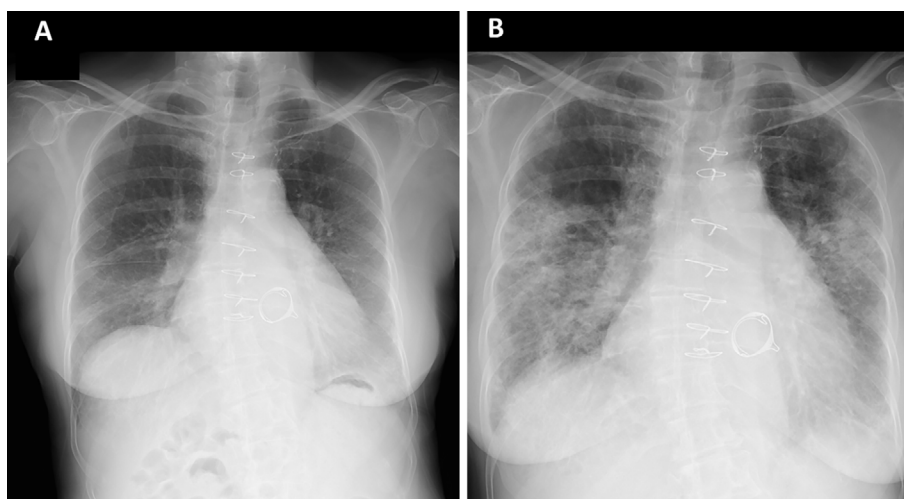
A chest radiograph taken before the start of bucillamine at the first visit to the local physician showing reticular shadows in the bilateral lower lung fields (A). A chest radiograph taken at initial presentation showing infiltrative opacities in addition to reticular shadows in the bilateral middle and lower lung fields (B).
